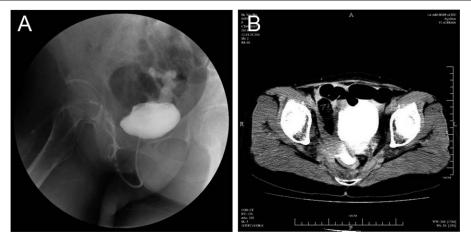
(A) The voiding cystourethrography demonstrates a rectovesical fistula. (B) The computed tomography (CT) urography showing contrast extravasation from bladder to rectum.
